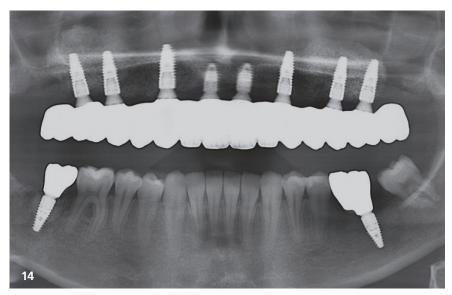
One-year radiograph confirms implant success and stability.
